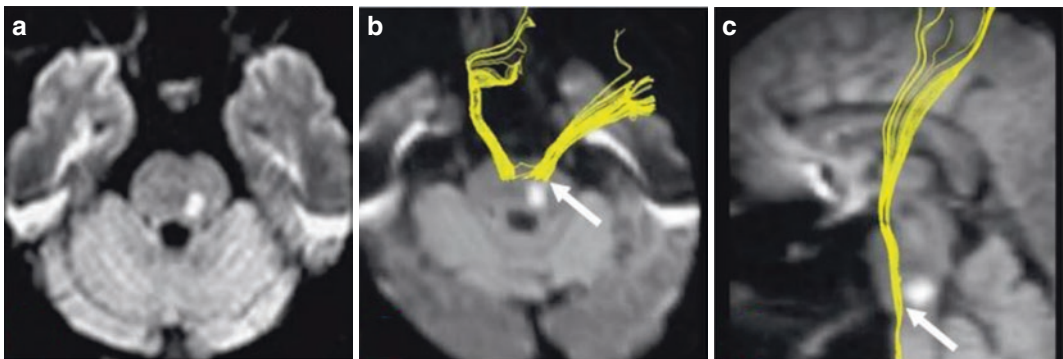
Left pontine infarction. A 57-year-old male patient who presented with numbness and weakness of the right limbs for 1 d. The patient's limb motor dysfunction recovered significantly after 2 weeks. Transverse DWI
